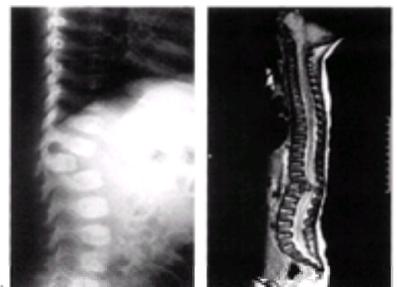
Fracture-dislocation of the spine in a 10-month-old infant, a victim of abuse, who had incomplete paraplegia. A: Lateral radiograph of the spine. B: Magnetic resonance image showing cord compression. (Courtesy of Keith Gabriel, M.D., Cardinal Glennan Children's Hospital, St. Louis, Missouri.)
